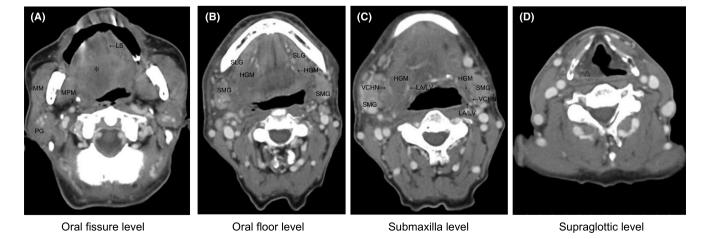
Axial CT images. (A) Oral fissure level. (B) Oral floor level. (C) Submaxilla level. (D) Supraglottic level. The CT images reveal the following findings: The right tongue parenchyma is diffusely inflamed. The right hyoglossus muscle is significantly thickened along its entire length. Inflammation spreads to the submandibular and visceral spaces. HGM, hyoglossus muscle; MM, masseter muscle; MPM, medial pterygoid muscle; LS, lingual septum; PG, parotid gland; SMG, submandibular gland; SLG, sublingual gland; LA, lingual artery; LV, lingual vein; VCHN, vena comitans of hypoglossal nerve. Asterisk reveals diffuse inflammation of the tongue parenchyma. Triangle reveals laryngeal edema.
